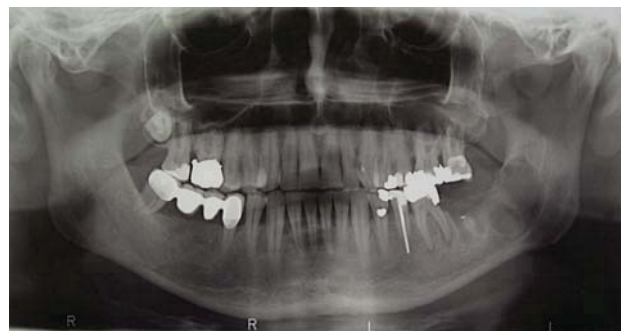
Orthopantomographic radiography before the surgical intervention
